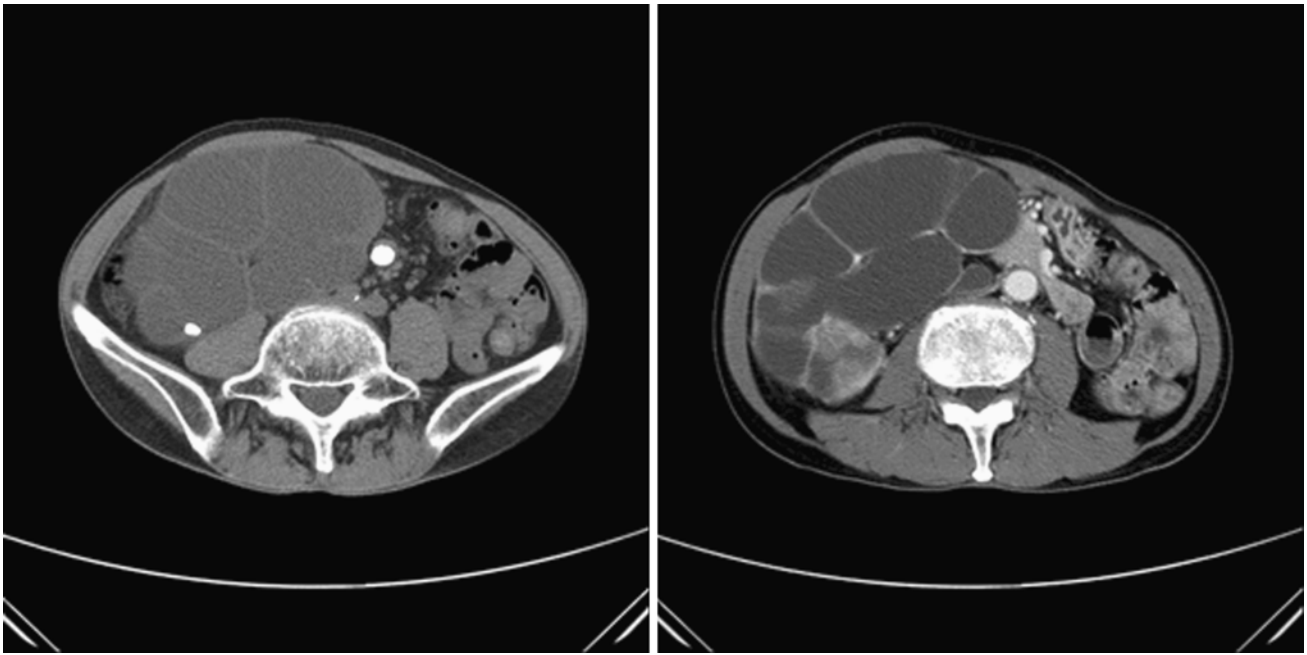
Preoperative CT scan showed severe hydronephrosis, thin parenchyma of the right kidney, several calyceal stones (<10 mm) and a right upper ureteral stone (22 mm)
